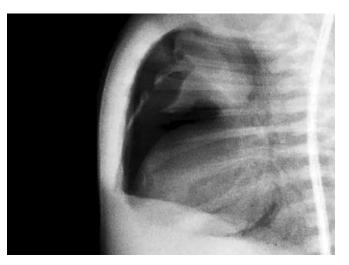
Pneumomediastinum lateral chest X-ray (showing air behind the sternum)
